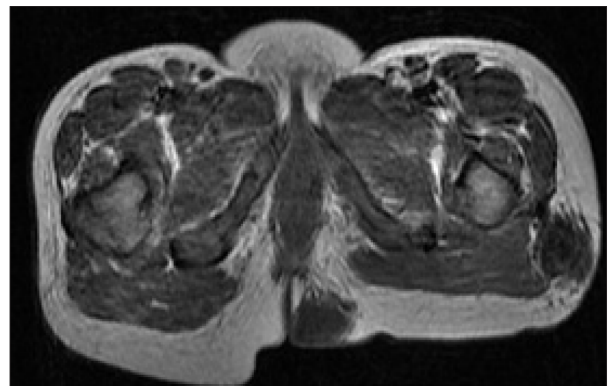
MRI of calcinosis (nodular hypointensities with subcutaneous fat tissue calcification at the left hip joint level and the left gluteus).
